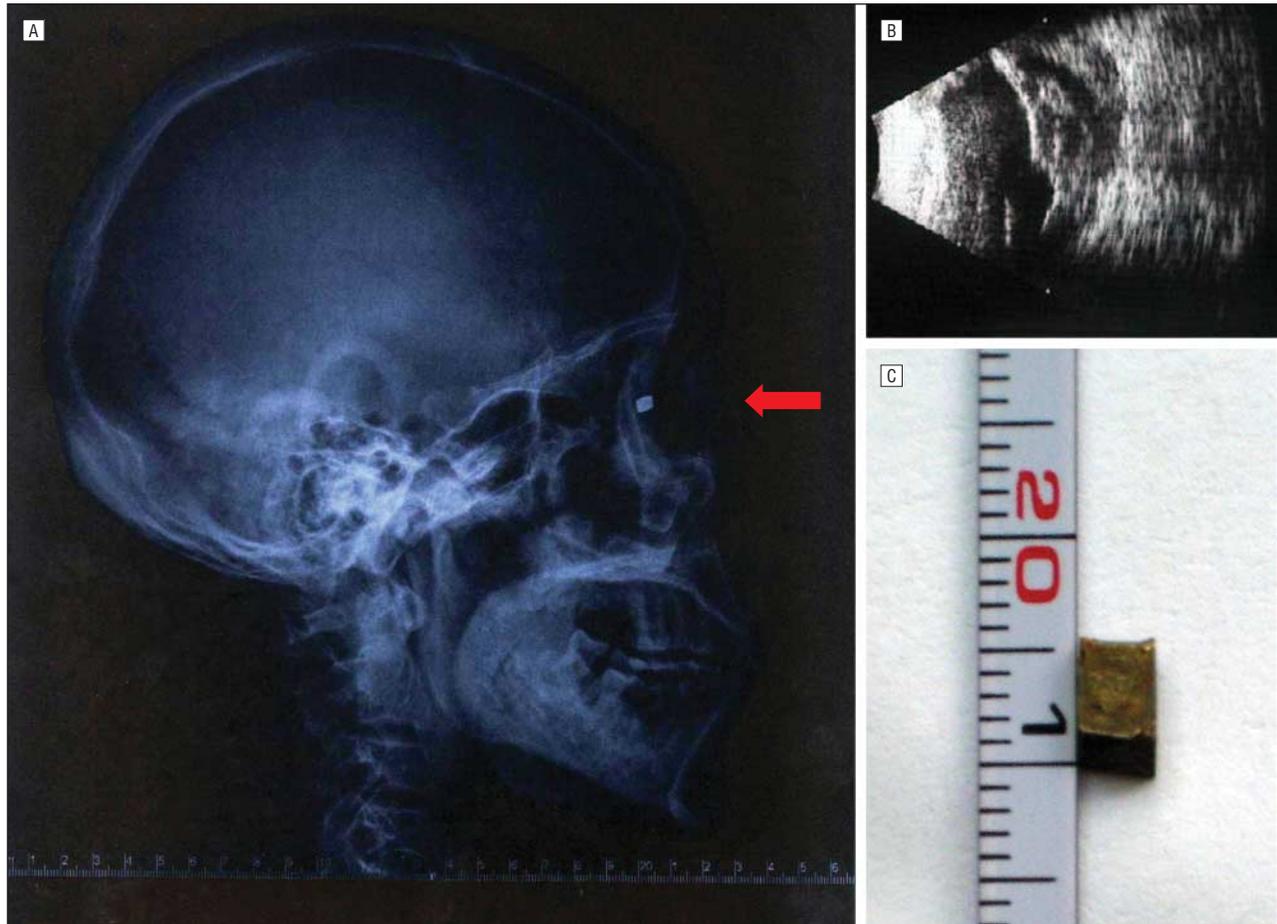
A 38-year-old man with an accidental perforating ocular injury. A, Lateral x-ray of the patient with a retrobulbar foreign body (arrow). B, Preoperative ultrasound examination reveals retinal detachment and combined vitreous and subretinal hemorrhage. C, The cubic iron foreign body measuring $6 \times 3 \times 3$ mm.
